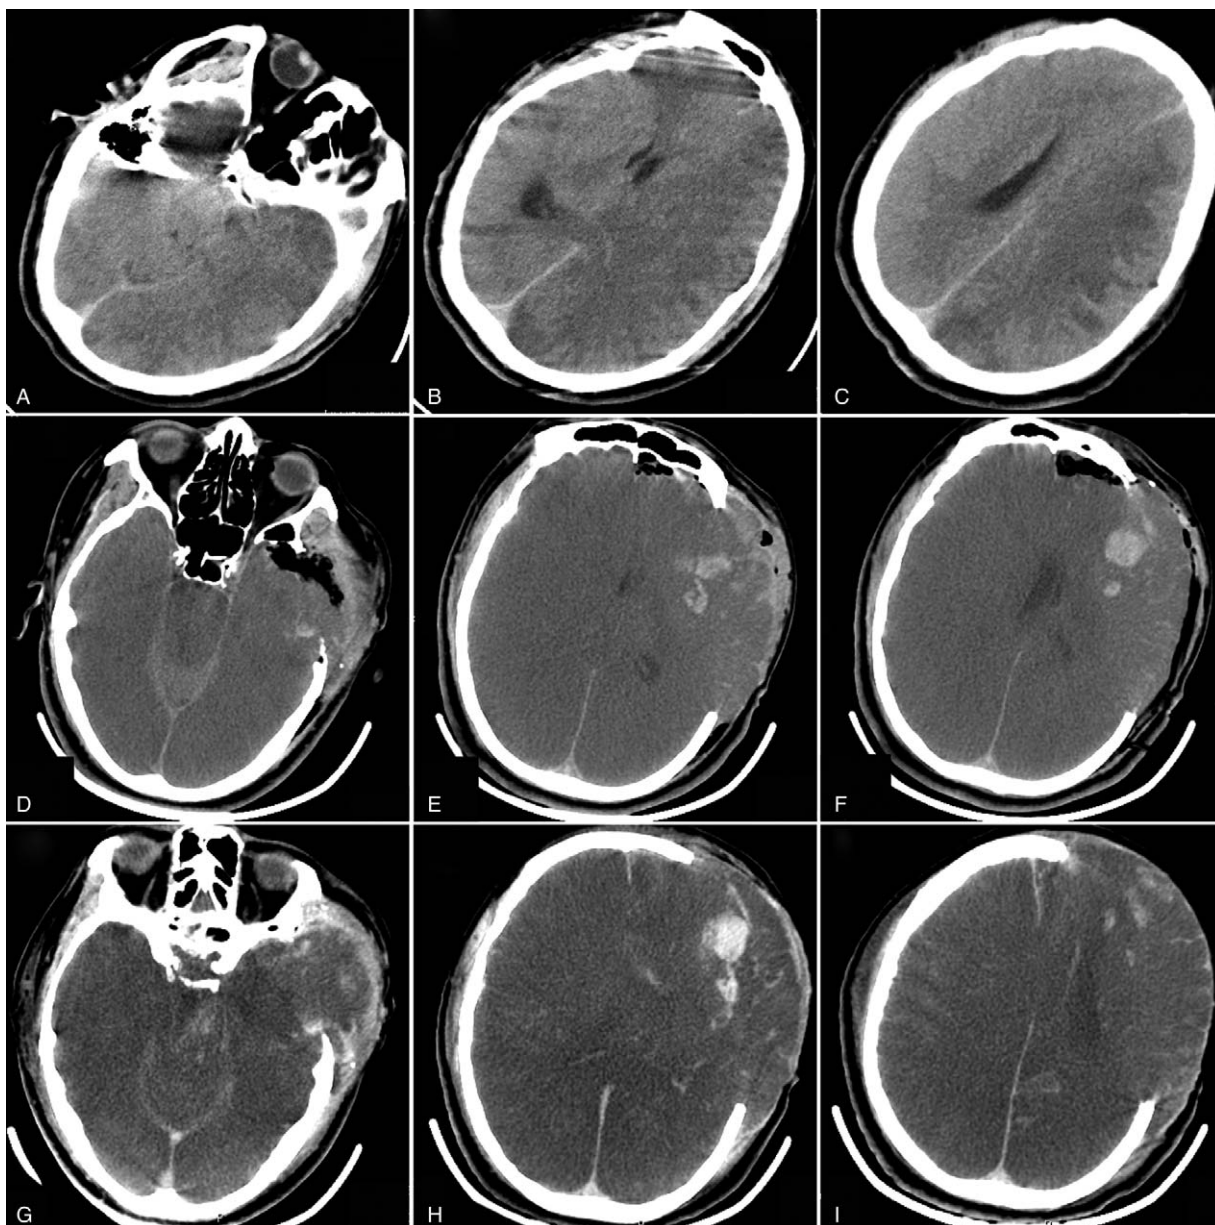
Computed tomography scan after carotid artery angiography. (A–C) Nineteen hours after the balloon dilatation, the left frontal, temporal, and parietal lobes showed low-density shadows and brain sulci and gyri become shallow. (D–F) Twenty-six hours after the balloon dilatation, computed tomography scans showed a low-density shadow on the left hemisphere, where sulci and gyri of the brain disappear and the midline shifts. (G–I) On the 6th day postoperation, acute diffuse brain swelling, subarachnoid hemorrhage, and cerebral hemorrhage appear in the left frontal and temporal lobes.
